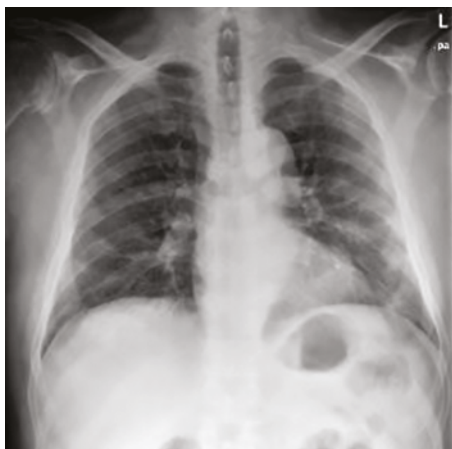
Sample X-ray image of COVID-19 [4]
